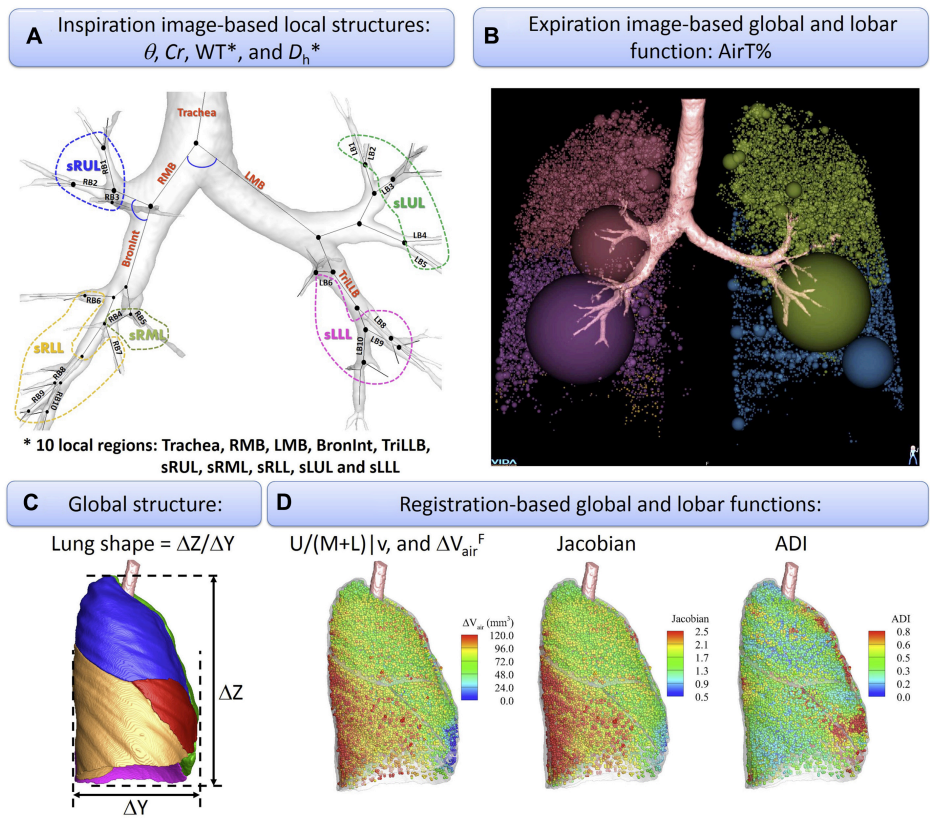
Clinical CT Measurements of Pulmonary Structure and Function
